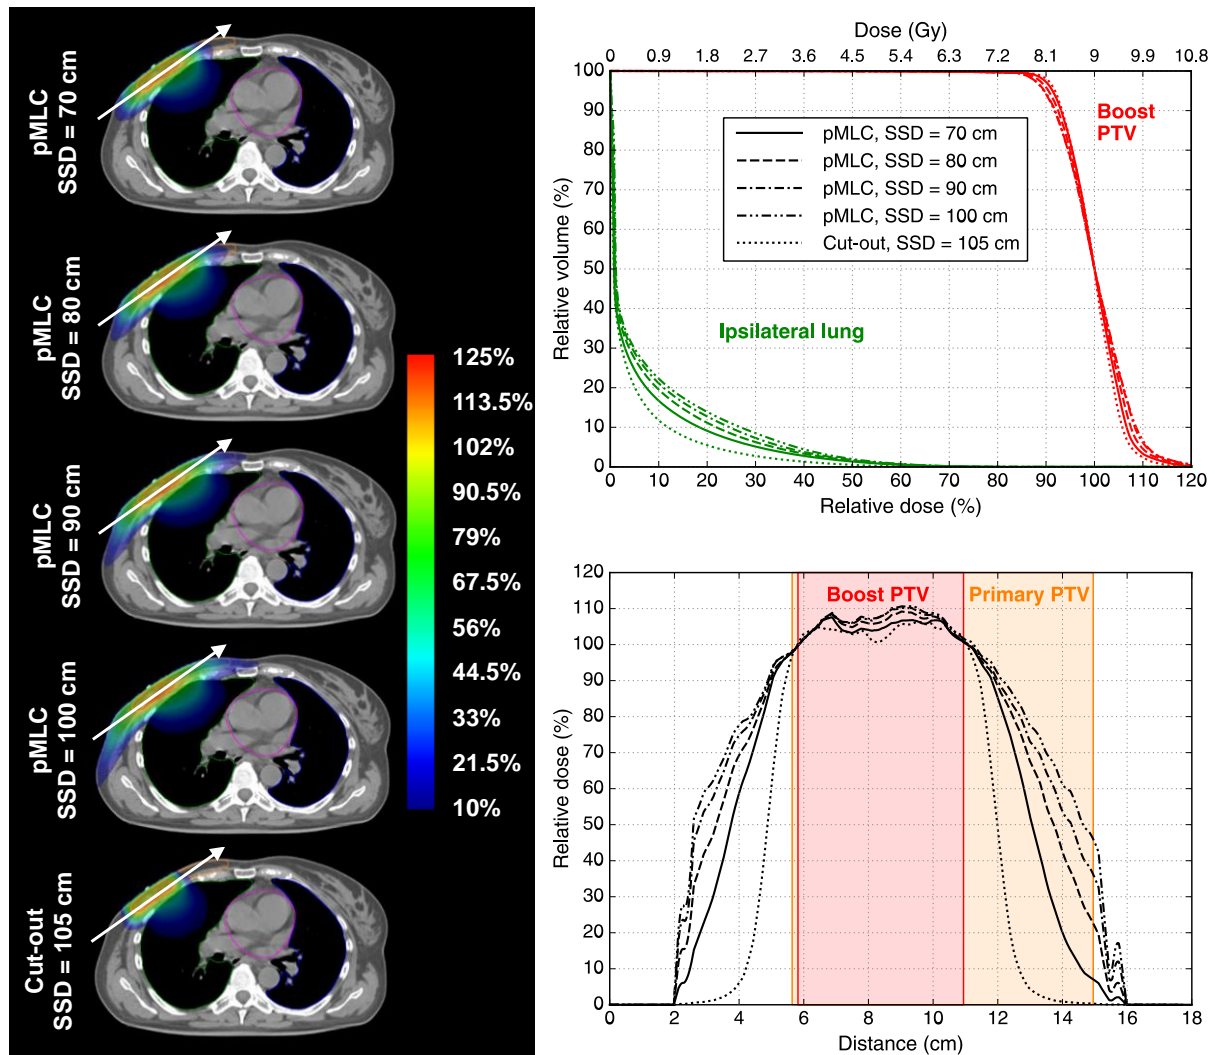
Dose distributions (left) and DVHs (top right) of TrueBeam 6 MeV 1E plans created for the right breast boost case and dose profiles (bottom right) indicated by a white arrow on the dose distributions. The legend of the DVHs also applies to the dose profiles. The contours of the boost PTV (red), primary PTV (orange), ipsilateral lung (green), contralateral lung (blue) and heart (magenta) are visible on the transversal CT images.
